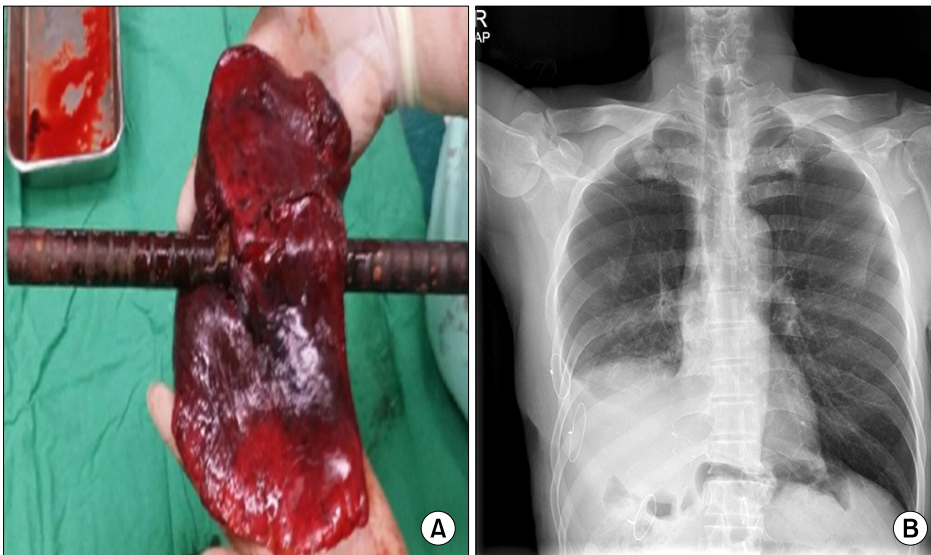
(A) The right lower lobe was penetrated by the steel bar. (B) A chest X-ray was taken just before discharge.
